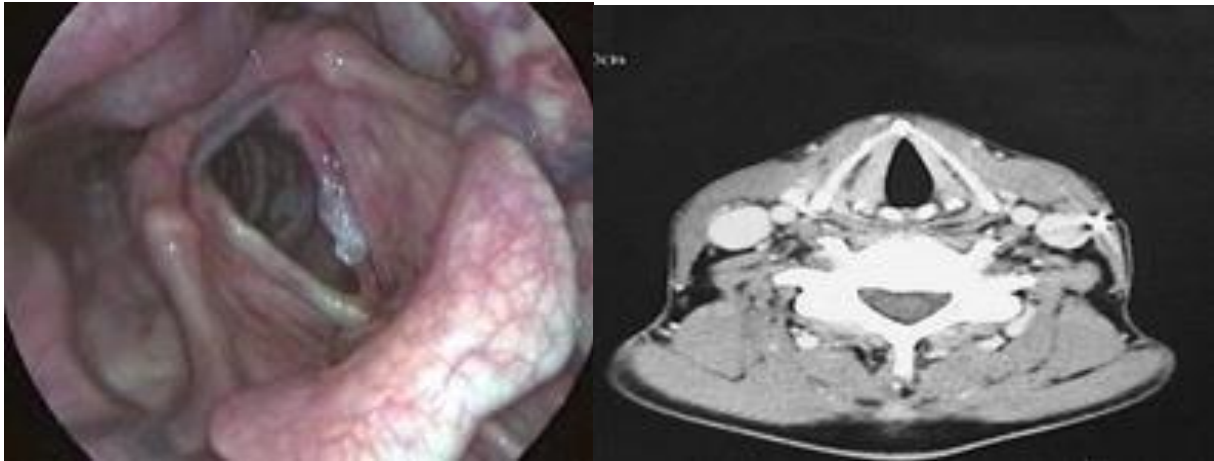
Right Image-Direct laryngoscopy: tumor of the anterior 1/3 of the right CV without reaching the CA. Mobility is preserved. Left image-CT scan: normal (false negative).
